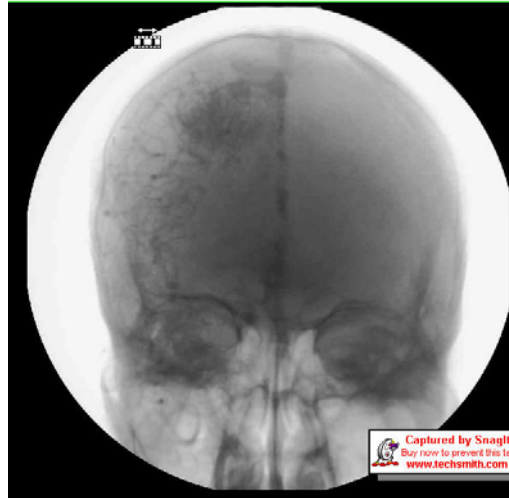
Image-Brain CT focus on Routine (3/26)
